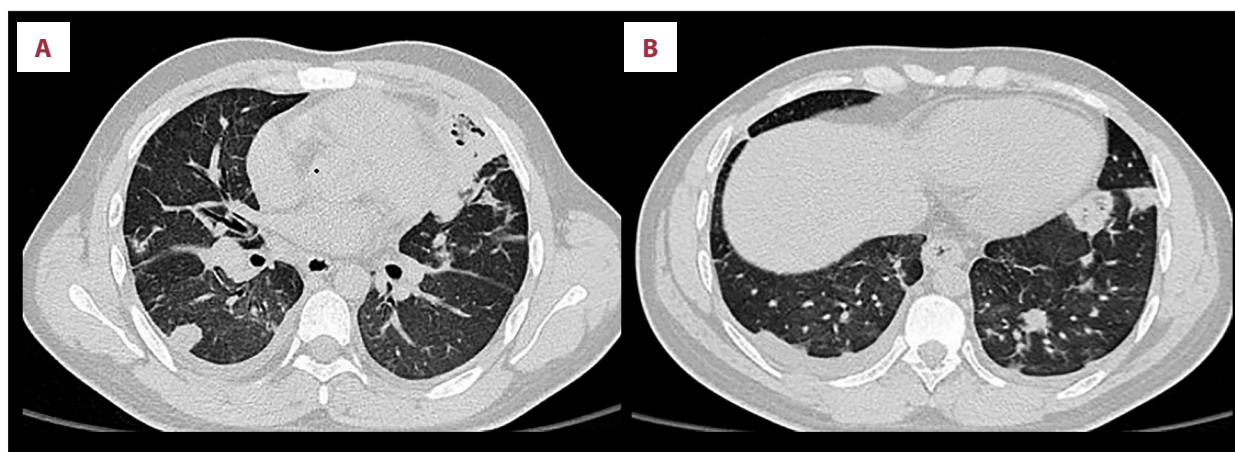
(A, B) Non-contrast chest computed tomography demonstrates bilateral heterogeneous pulmonary opacities with interlobular septal thickening, associated with multiple randomly distributed nodular and pseudonodular lesions in both central and peripheral locations, as well as air bronchograms in both lung fields. Bilateral pleural effusions with associated compressive atelectatic changes are also observed.
